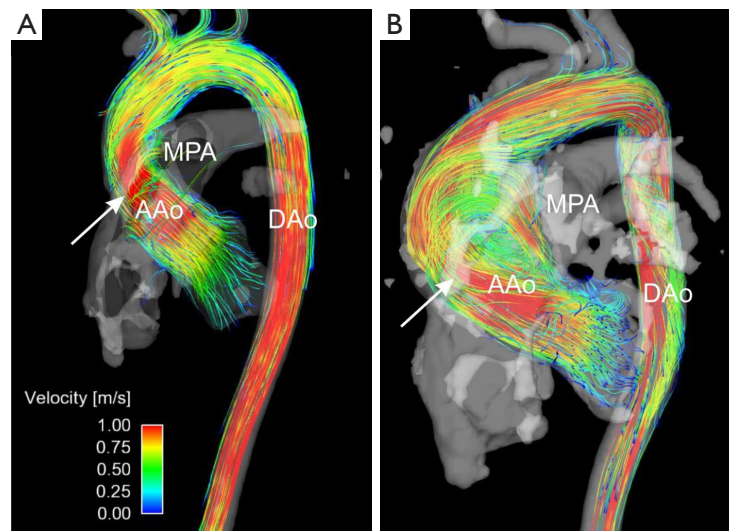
Two examples of systolic 3D streamline representation of 4D flow MRI data in patients with BAV. In both cases, a posteriorly directed high velocity flow jet is present in the ascending aorta suggesting aortic stenosis as a result of the BAV (white arrow). (A) BAV patient with minimal ascending aortic dilation; (B) BAV patient with a dramatically enlarged ascending aorta aneurysm with flow jet impingement. There is also a large amount of helical flow occurring within the aneurysm. This patient underwent valve-sparing ascending aorta repair. AAo, ascending aorta; MPA, main pulmonary artery; DAo, descending aorta; BAV, bicuspid aortic valve; MRI, magnetic resonance imaging.
